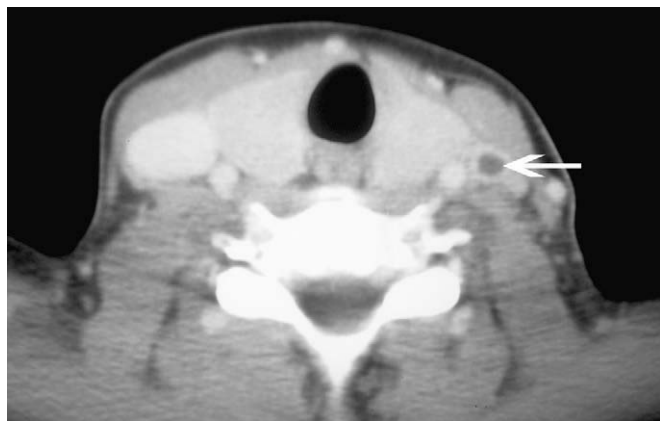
Transverse contrast-enhanced computed tomography through the neck at the level of the thyroid gland with evidence of thrombosis in the left internal jugular vein (arrow).
